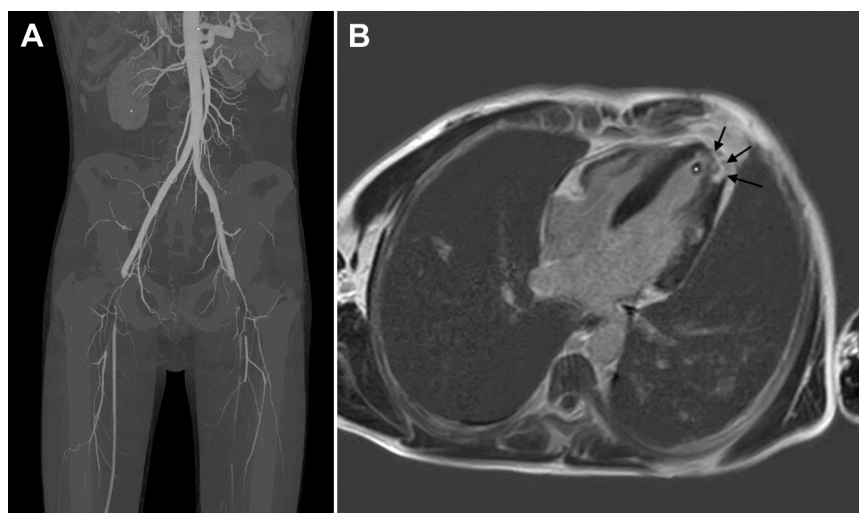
(A) Computed tomography angiography: sharp and abrupt occlusion of the 2 common femoral arteries, segmental thrombosis of the left internal iliac artery. (B) Cardiac magnetic resonance imaging: subendocardial and almost transmural late gadolinium enhancement, with sharp margins, in the mid and distal inferolateral and inferior walls, consistent with myocardial infarction (black arrows), and apical centimetric thrombus adjacent to the lesion (white star).
